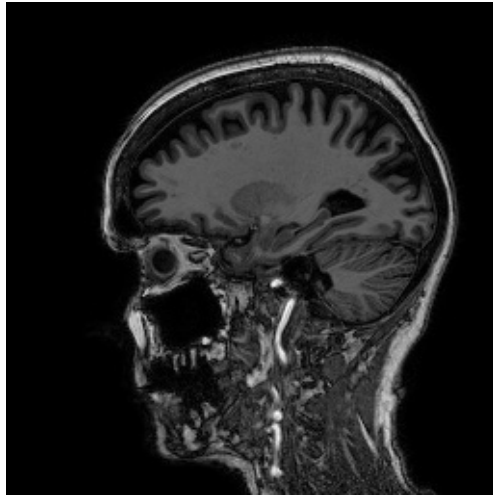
structural MRI image of Alzheimer patient (from the dataset ADNI1-Annual-2-Yr-3T-8-03 2019)
